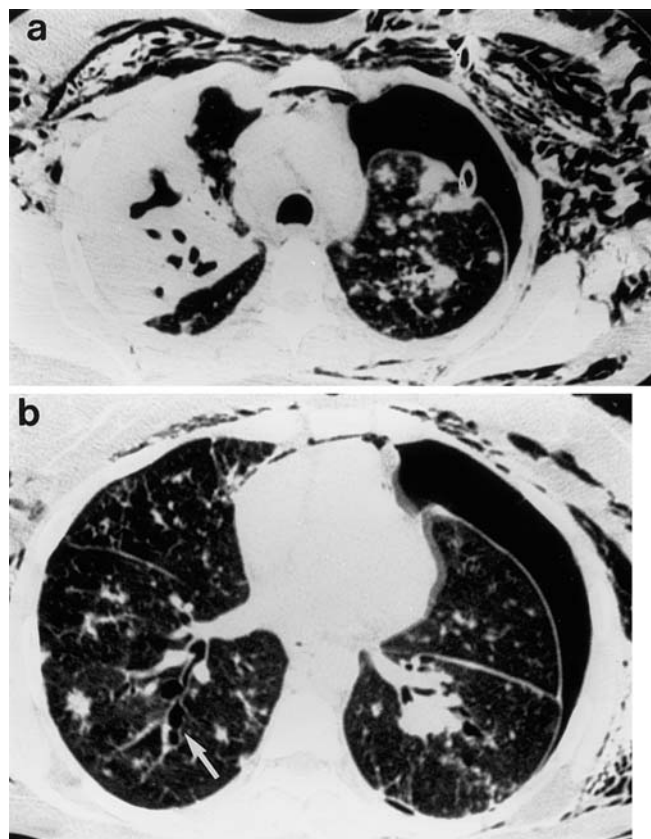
Allergic bronchopulmonary aspergillosis with invasive aspergillosis. A patient with longstanding ABPA presented with a persistent right upper lobe infiltrate which progressed despite steroid and antifungal therapy. a The CT scan shows dense consolidation containing bronchiectatic airways and probable cavitation in the right upper lobe, and multiple nodules in the left upper lobe. There is a pneumothorax on the left with extensive surgical emphysema and a chest drain in situ. b An image from a lower cut shows the proximal bronchiectasis (*arrow*) typical of allergic ABPA and more parenchymal nodules. The patient deteriorated despite systemic antifungals and the post-mortem examination showed invasive pulmonary aspergillosis, with dissemination to the mediastinum, liver and spleen
